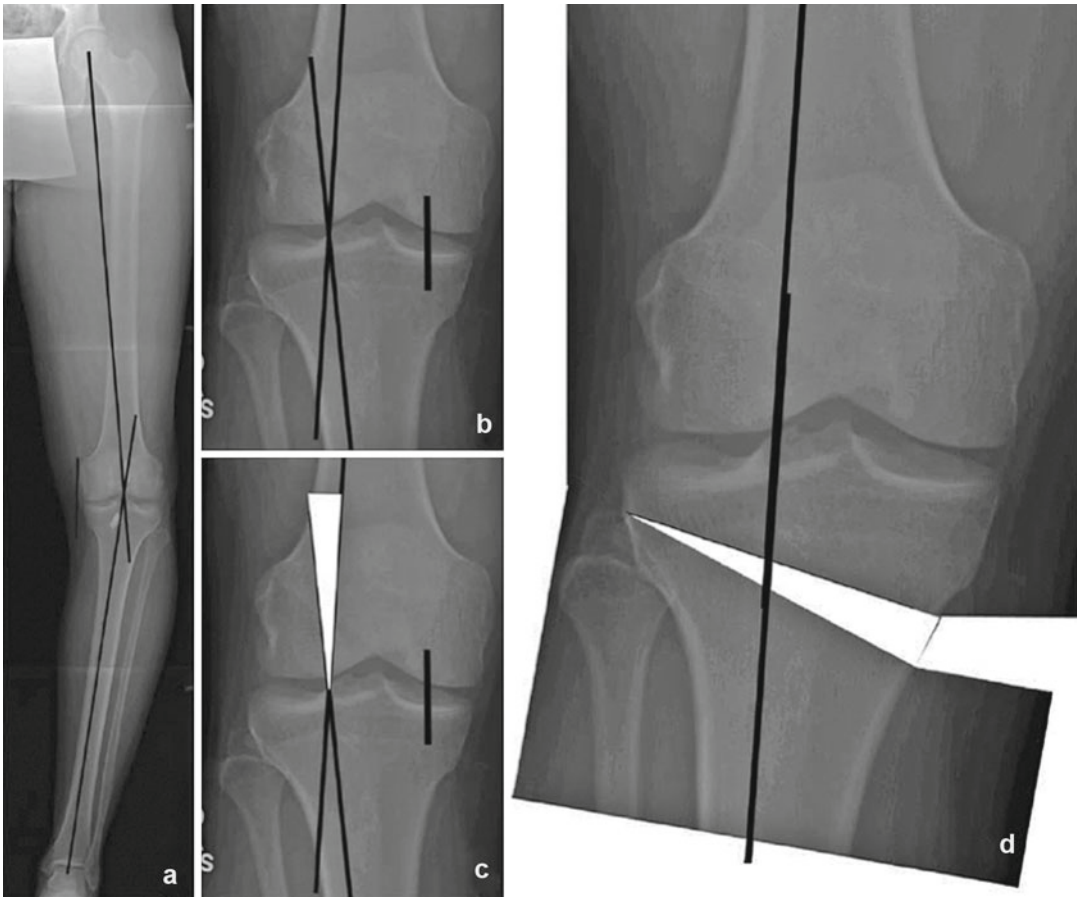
A case of double varus left knee with a failure of previous ACL reconstruction. The patient has both pre-existing varus alignment and lateral opening of the knee on a weight-bearing radiograph. (a) The right knee was used as a template for the correction of preexisting bony alignment. (b) The mechanical axis, shown as a short line, falls into the center of the medial compartment. The new weight-bearing lines are aligned at the point 62.5 % across
